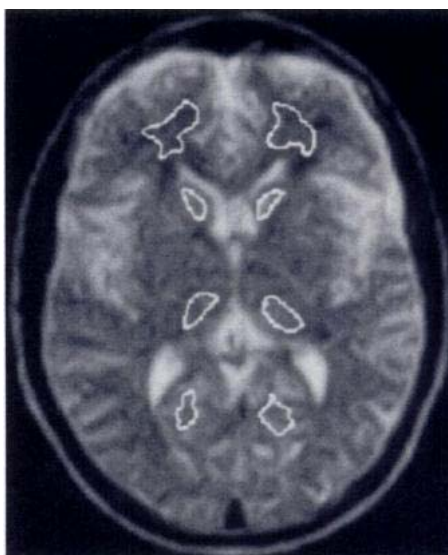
The small regions for which T_1 and T_2 were to be assessed ("regions of interest") were delineated on an MRI picture (4 areas on each side).³⁸
